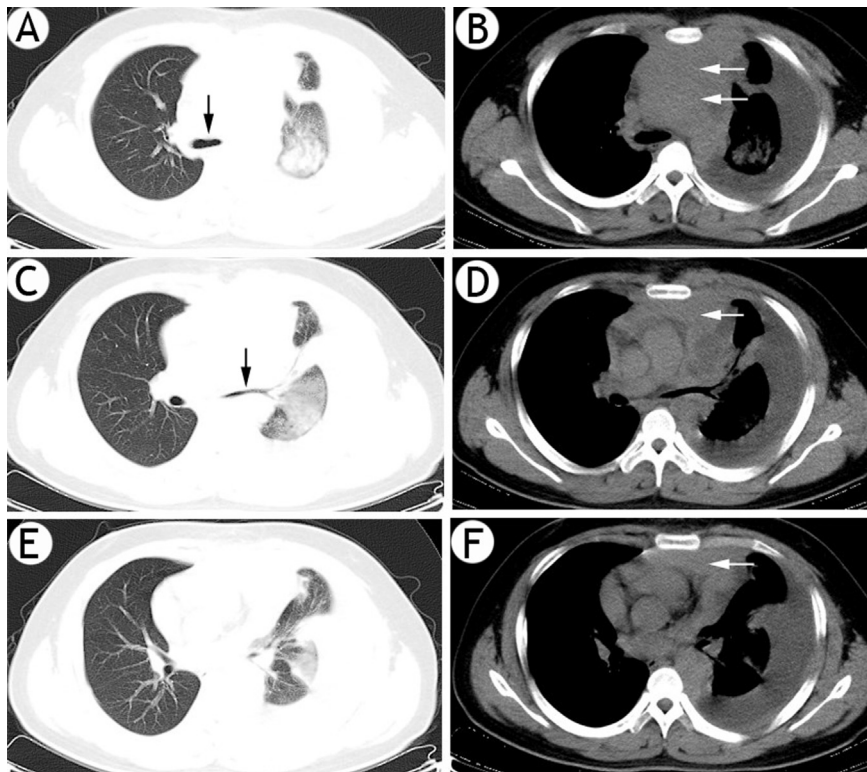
Chest computed tomography view of the patient. Chest CT showed left-sided pleural effusion, an anterior and middle mediastinal mass (B, D, F, white arrow) which resulted in contralateral shift and stricture of the tracheal (A, black arrow) and left mainstem bronchus stricture (C, black arrow). Chest CT at the level of heart demonstrating pleural thickening of the left hemithorax, left-sided pleural effusion and a light pericardial effusion (E, F).
